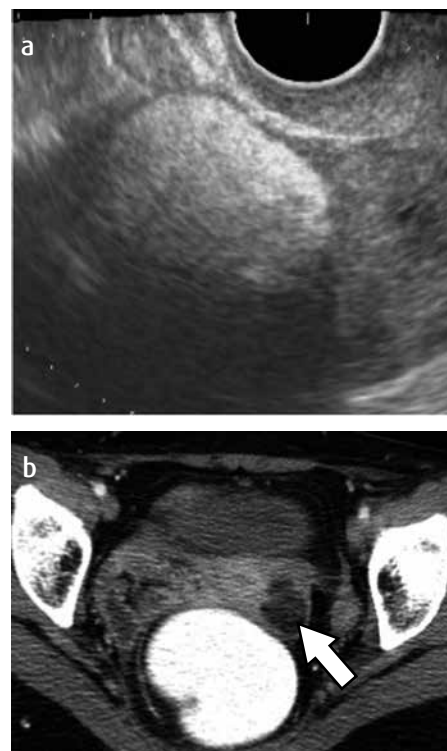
a) Transvaginal ultrasound. Hyper-echoic image, rounded, well defined, intramural located in the anterior wall that corresponds to lipoma. b) CT axial cut. Well-defined low density image, intramural, located in the uterine bottom (arrow) that corresponds to a lipoleiomyoma.
